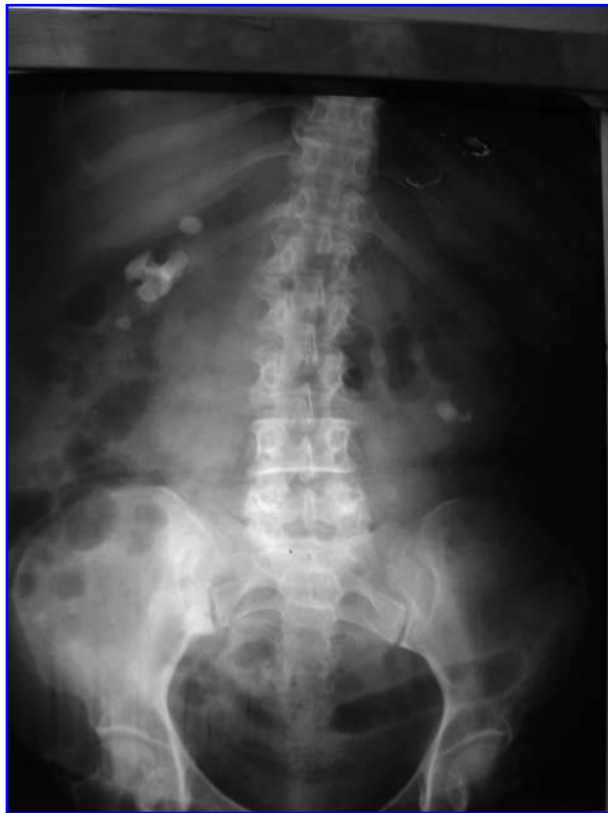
Radiograph shows large upper caliceal stones.
